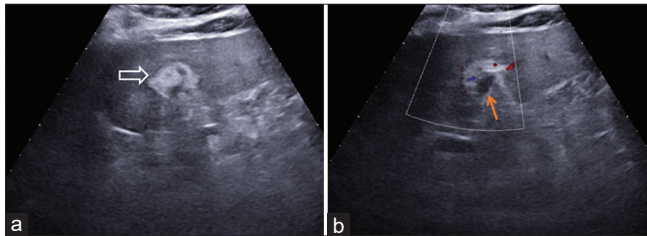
Transverse ultrasound images show thickened and echogenic falciform ligament (open white arrow in a). Doppler study shows an absence of flow within it (orange arrow in b)
